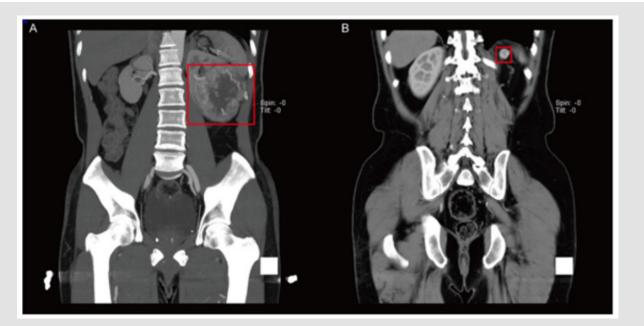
In the coronal plane of the enhanced CT, the primary renal tumor and perirenal intradiphular metastases can be significantly enhanced, and both exist in isolation.
